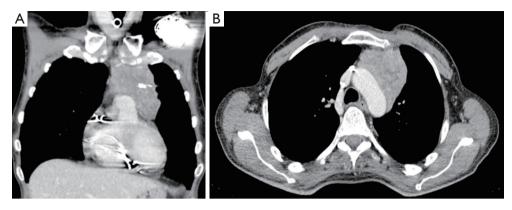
Coronal CT (A) and axial CT (B) images show marked reduction of the main lesion and pleural lesion after induction chemotherapy. CT, computed-tomography.
